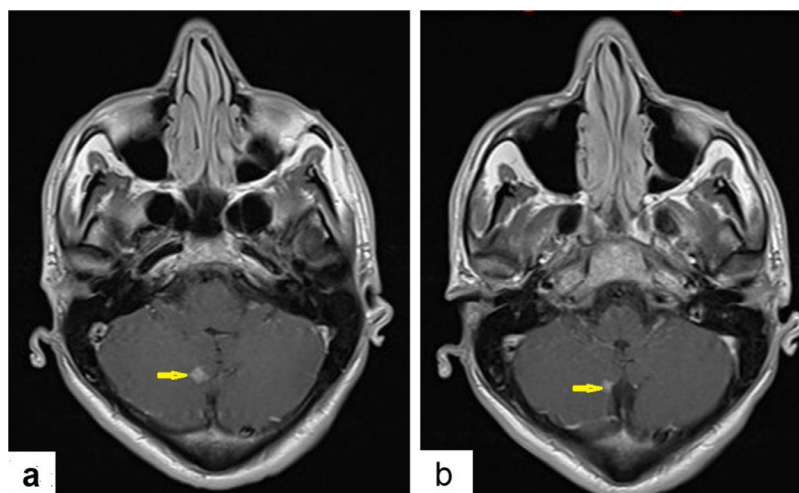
Selected axial images of magnetic resonance imaging of a 30-year-old male patient (A) postcontrast T1-weighted images of the posterior fossa revealed small enhancing lesion in the medial aspect of the right cerebellar hemisphere (arrow) likely represents small tuberculoma by the given history of patient TB meningitis, and (B) adjacent vascularity posterior to the lesion.
